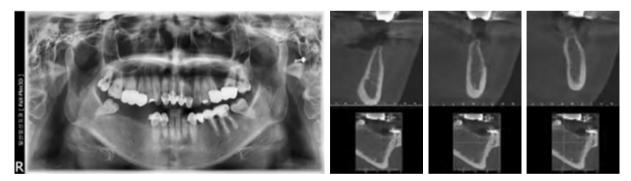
~2. Pre-operative radiograph
